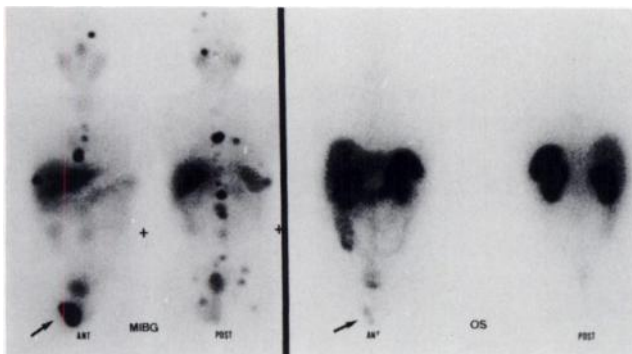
MIBG images from Patient 1 who has a malignant pheochromocytoma. (Left) Anterior and posterior views show multiple foci corresponding to bone metastases (vertebrae, ribs and skull) and a metastasis to the right testis (arrow). (Right) Anterior and posterior views of octreotide scintigraphy, demonstrating only an abnormal accumulation on testicular localization (arrow) contrasting with the absence of visualization of bone metastases.
